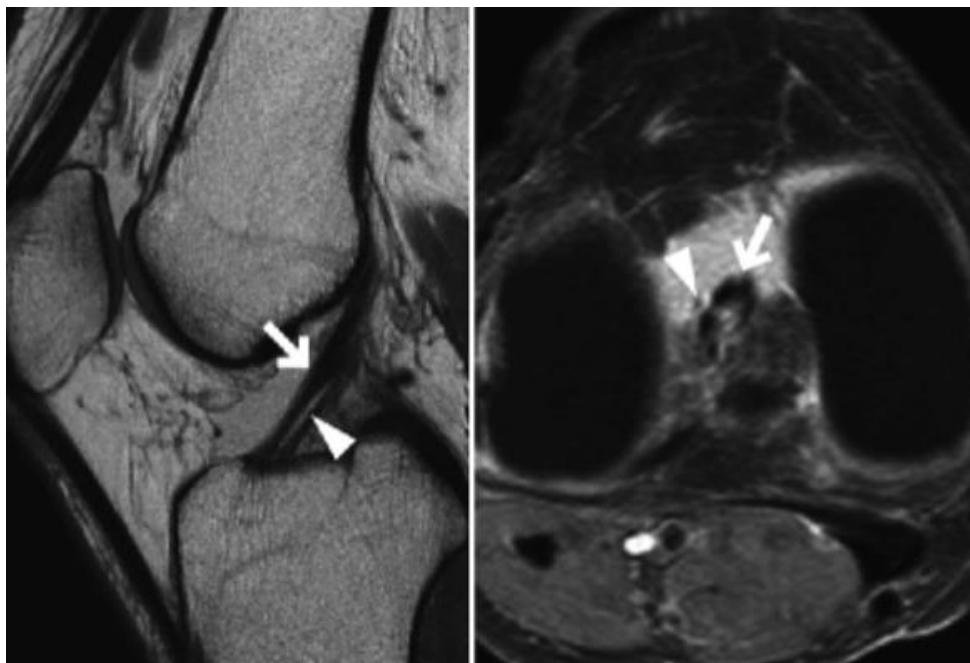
Sagittal and axial section of MRI Knee
